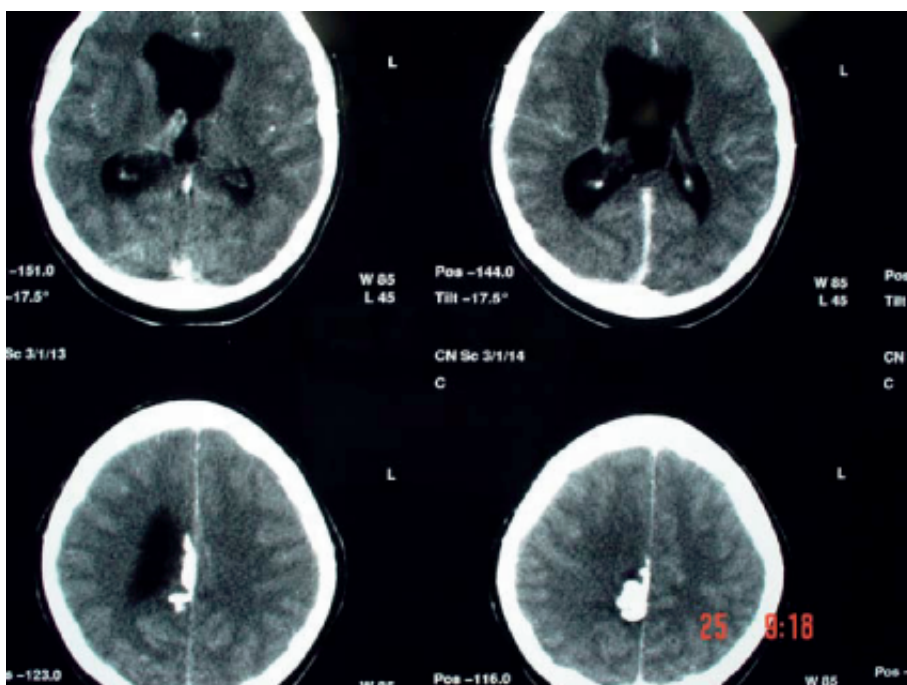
CT scan of the brain with intra-venous contrast shows comparative thick choroid plexus.
